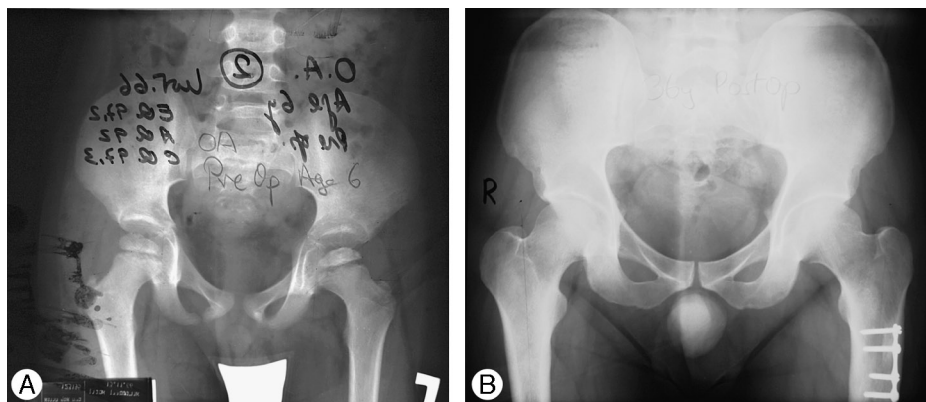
A, A preoperative AP radiograph of the pelvis of a 6-year-old boy shows LCPD of the left hip. B, At follow-up, when the patient was 42 years old, there was no pain or evidence of osteoarthritis of the affected hip. However, we believe this patient would have not undergone surgery by contemporary criteria.
